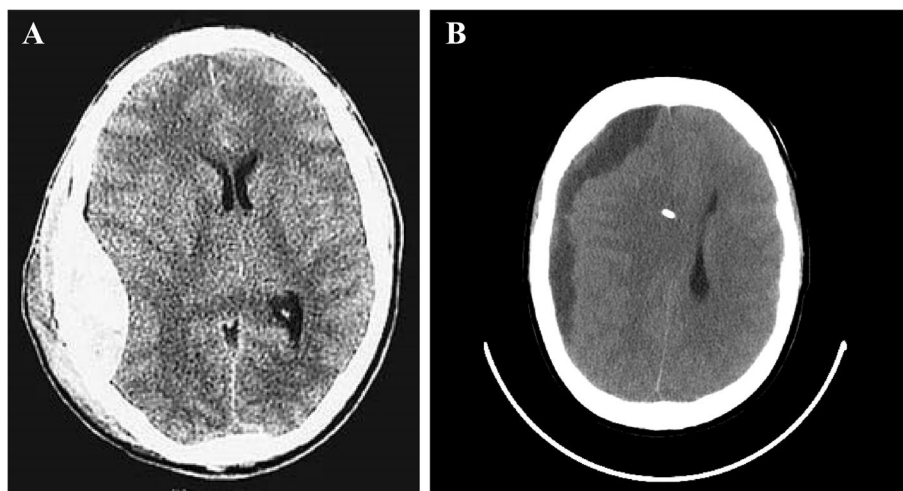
CT scans showing epidural (A) and subdural (B) hematoma causing ICP elevation, brain compression, and midline shift
